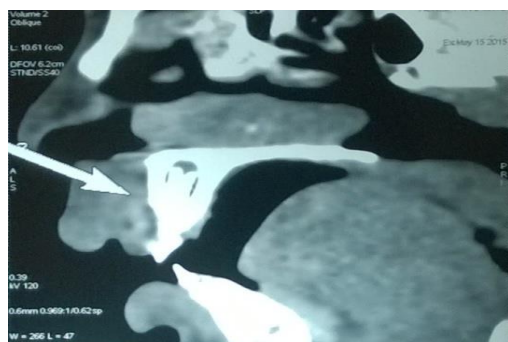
CT-scan maxilla
